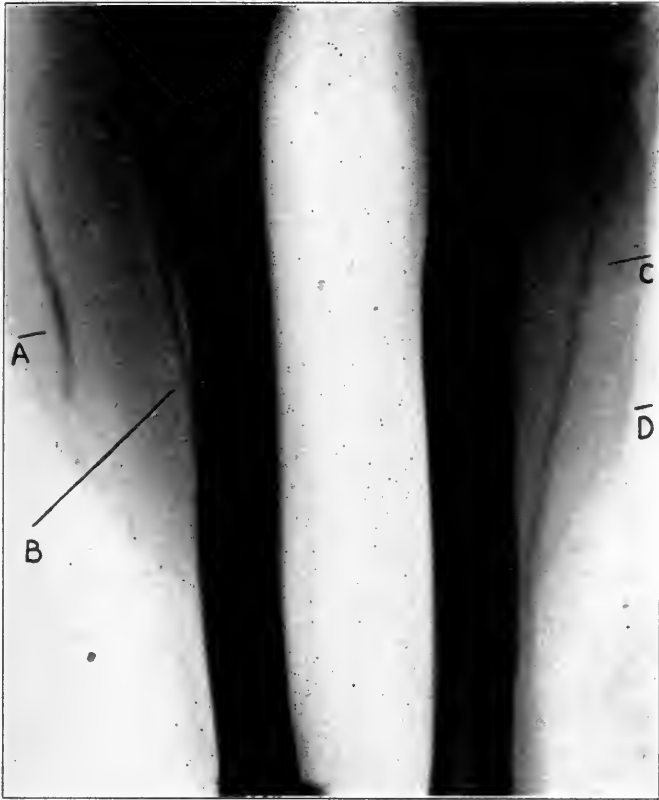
This roentgenogram shows that both fibulae transplanted without periosteum remained alive after five months. The transplanted periosteum into the left leg has produced a fine piece of new bone.
